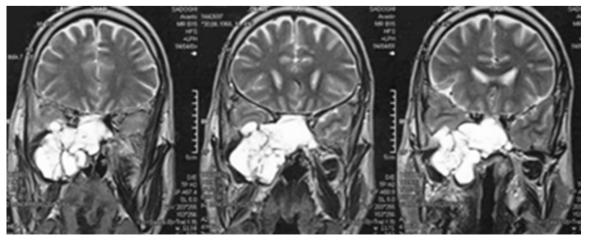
Last patient T2 Magnetic resonance imaging (MRI) shows the involvement of the skull base.
